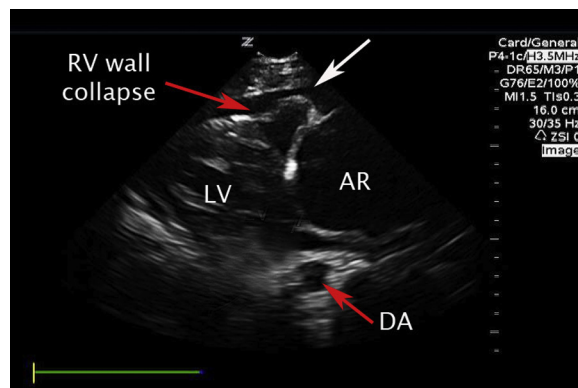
Parasternal long axis view of the heart showing an anechoic circumferential pericardial effusion (white arrow) causing right ventricular (RV) free wall collapse in diastole. AR = aortic root; DA = descending aorta; LV = left ventricle.
